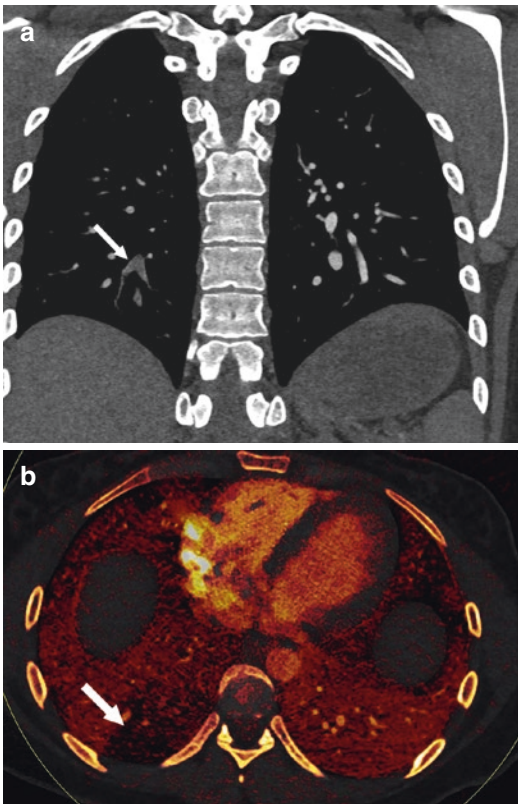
Acute pulmonary embolism. (a) Coronal CTA image shows a filling defect in right lower lobe segmental branches (arrow), which is consistent with an acute occlusive pulmonary embolus. (b) Axial dual-energy iodine map in the same patient shows a wedge shaped perfusion defect in the right lower lobe (arrow)
